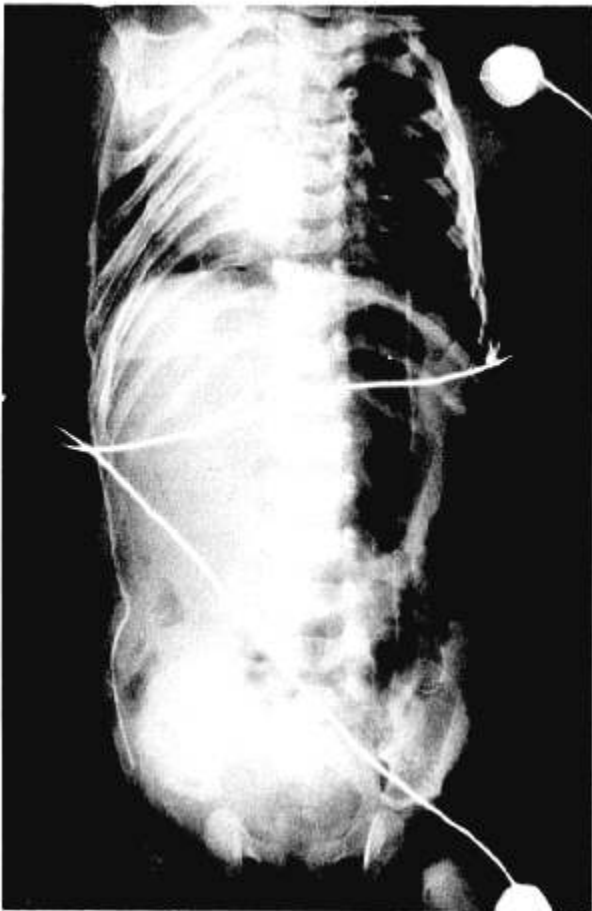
Whole body radiograph immediately after the operation in "twin B."
